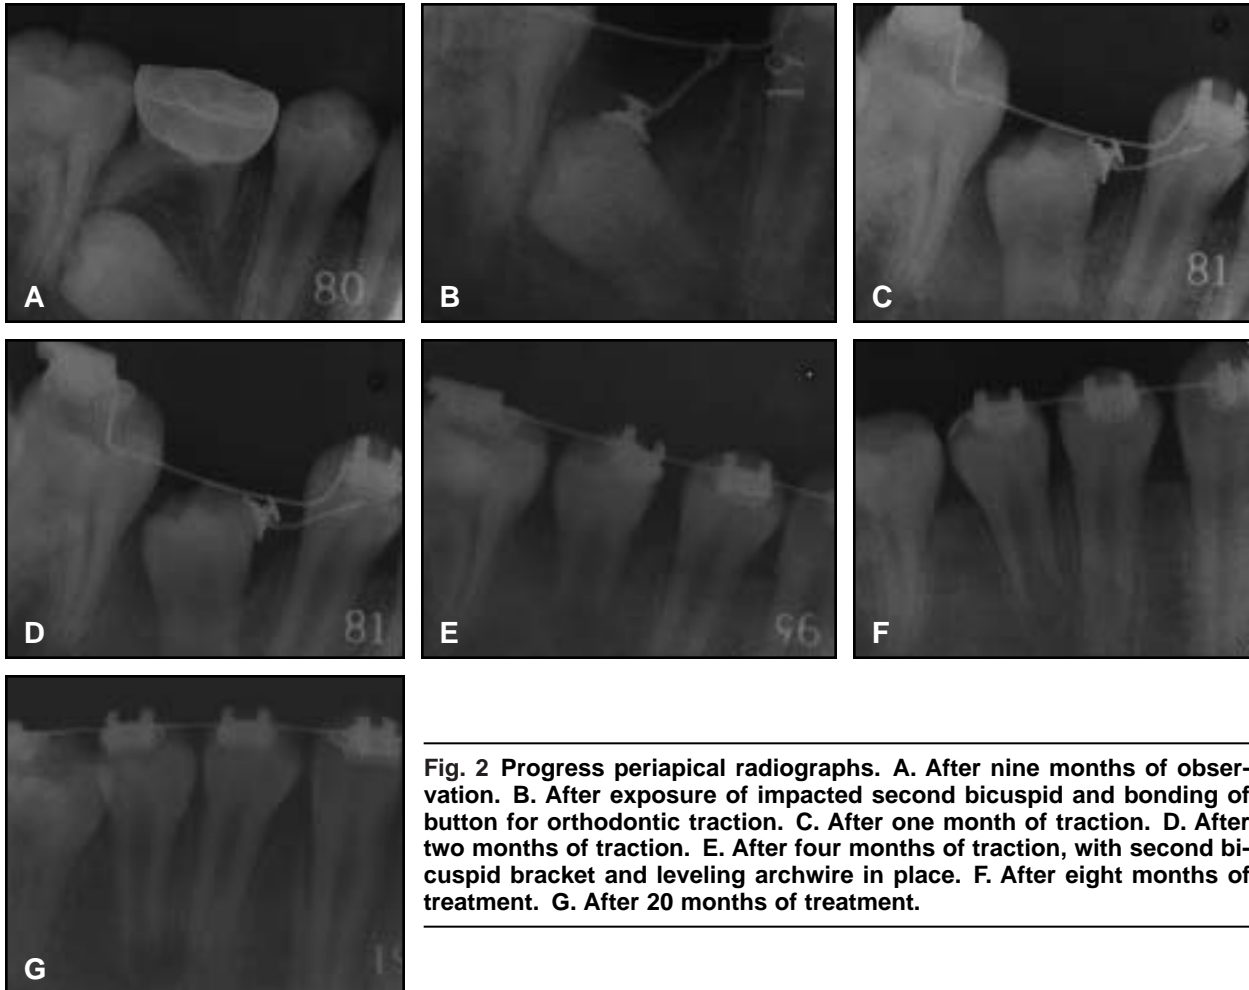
Progress periapical radiographs. A. After nine months of observation. B. After exposure of impacted second bicuspid and bonding of button for orthodontic traction. C. After one month of traction. D. After two months of traction. E. After four months of traction, with second bicuspid bracket and leveling archwire in place. F. After eight months of treatment. G. After 20 months of treatment.
